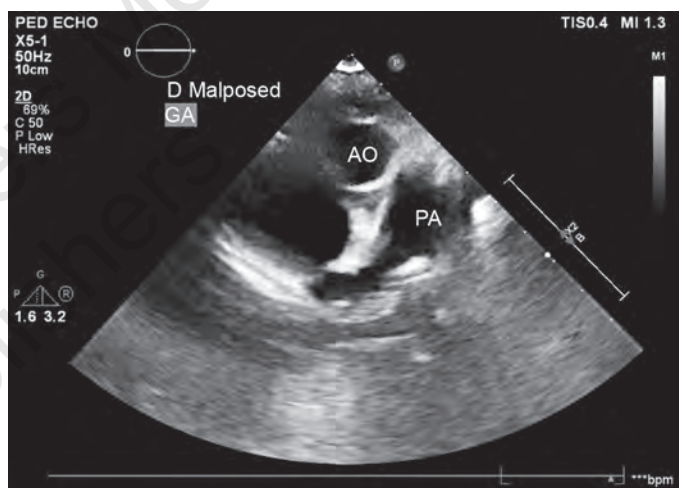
D-TGA: Parasternal short-axis view showing AO to the left and anterior to pulmonary artery.
